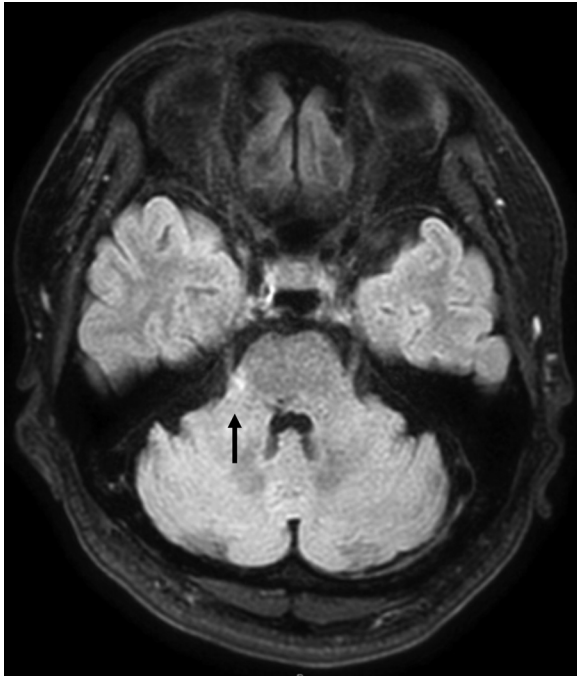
Postoperative MRI imaging at 10 mo Fluid-attenuated inversion recovery image. Brain MRI at 10 mo after the TVE showing decreased pons edema. MRI, magnetic resonance image; TVE, transvenous embolization.
